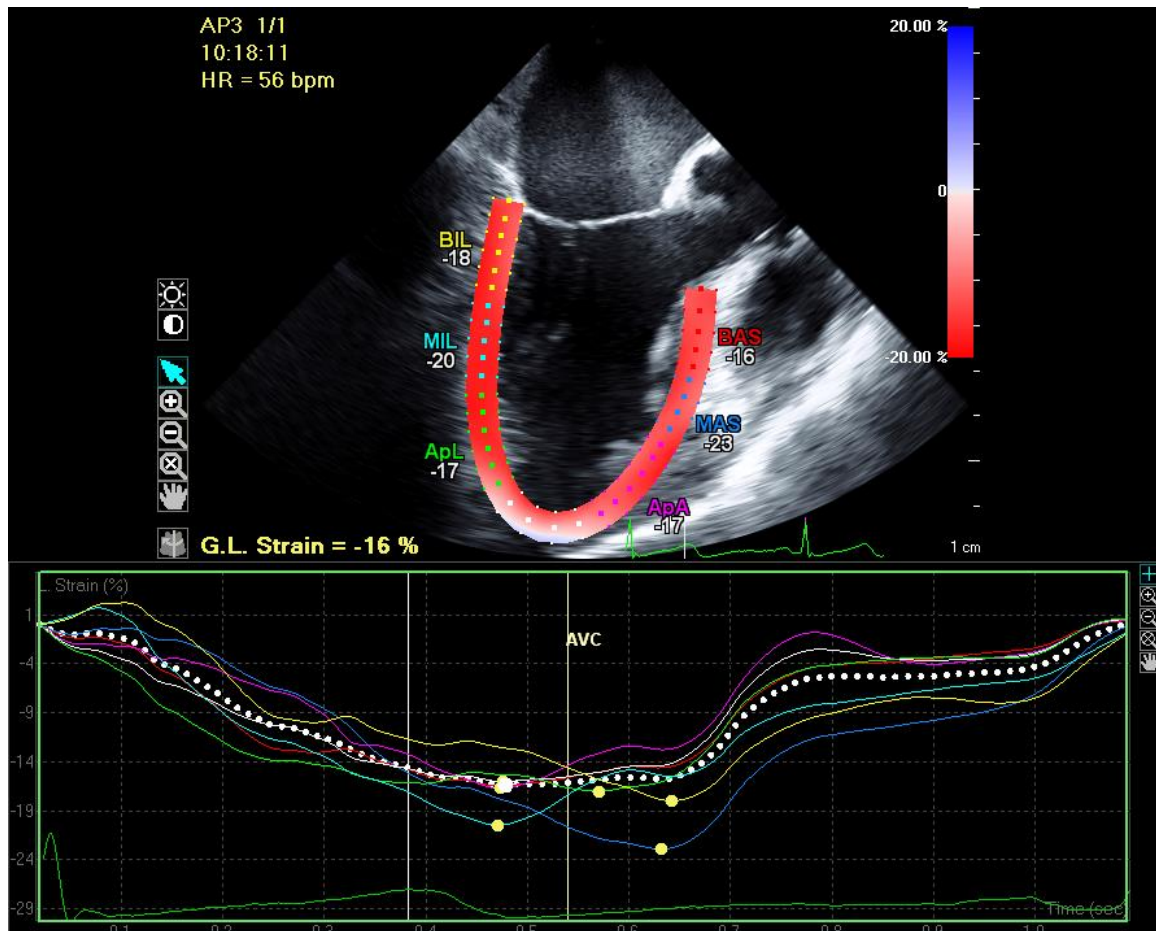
Mid-esophageal long axis echocardiographic view of pt no 9 depicting the left ventricle (LV), where the myocardial walls are divided into six segments distinguished by color-coded labels. Segmental strain measurements are shown adjacent to each segment. BAS – basal anteroseptal, MAS – mid anteroseptal, ApA – apical anterior, BIL – basal inferolateral, MIL – mid inferolateral, ApL – apical lateral.
